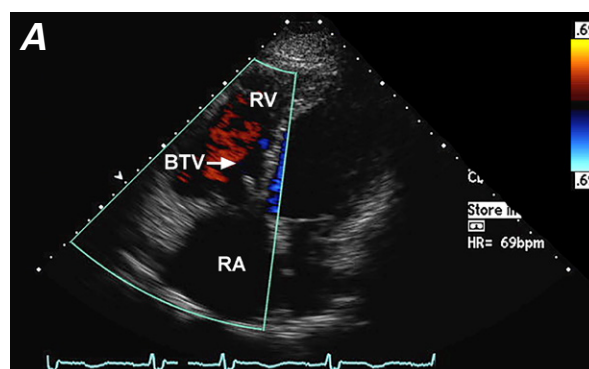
Postoperative transthoracic echocardiograms. A) Four-chamber view (color-flow Doppler mode) shows the bio-prosthetic tricuspid valve (BTV) and less right atrial and right ventricular dilation. B) Four-chamber view shows improved right ventricular function.
